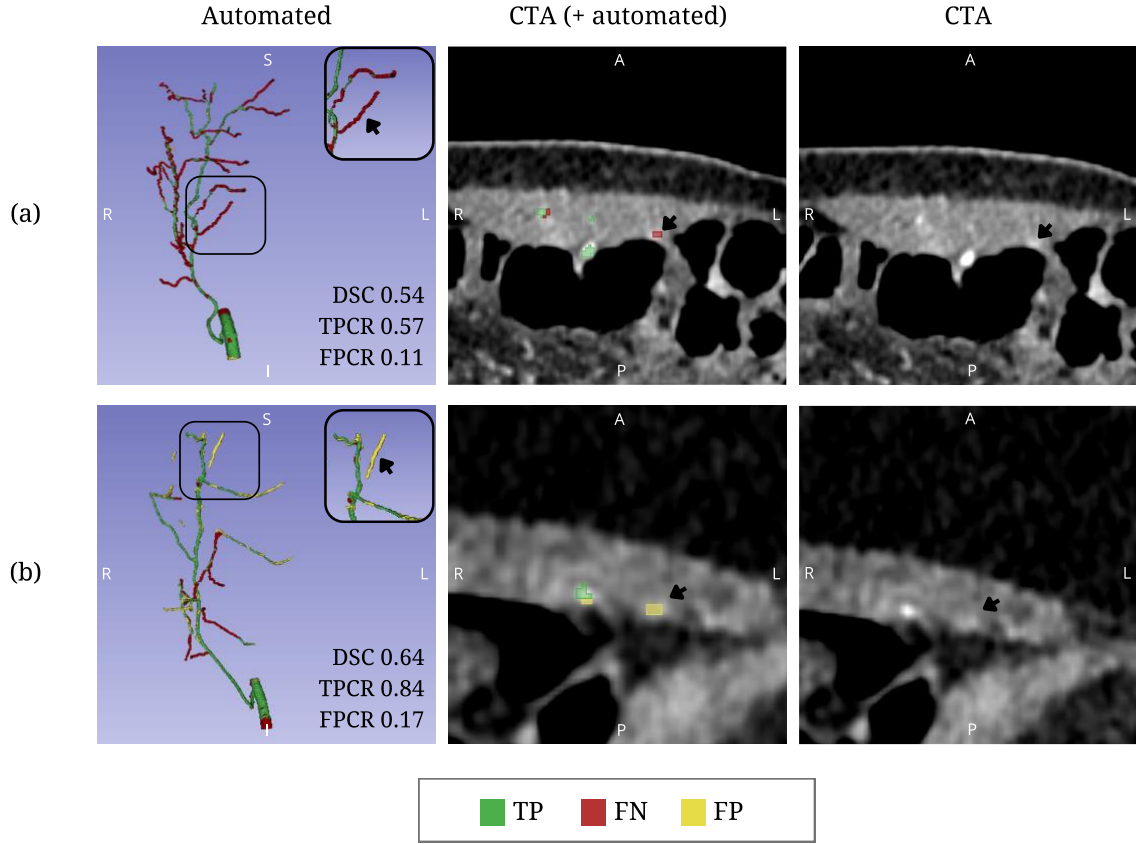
Visualization of automated segmentation outcomes for two test cases. The axial slices of the CTA scans are presented using a CT-abdomen window leveling in 3D Slicer. (a) Visualization of a false negative automated perforator; (b) Visualization of a false positive automated perforator that was missed in the manual annotation. DSC = Dice similarity coefficient; FPCR = false positive centerline rate; TPCR = true positive centerline rate; TP = true positives; FN = false negatives; FP = false positives.
